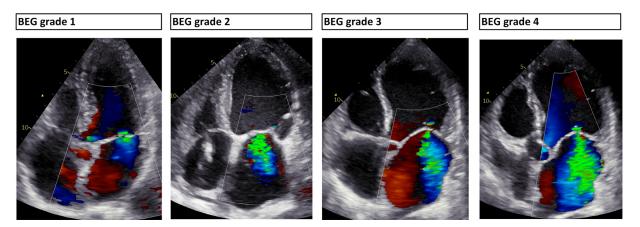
Examples of the best educated guess (BEG) color Doppler grading A grade 1 color Doppler jet is considered when a small single jet is observed in the left atrium (LA); grade 2 mitral regurgitation (MR) extends deeper into the LA without reaching the LA roof; grade 3 involves jets reaching the LA roof, being either central or eccentric jets; grade 4 is an MR jet (almost) filling the entire LA. (BEG: best educated guess)
